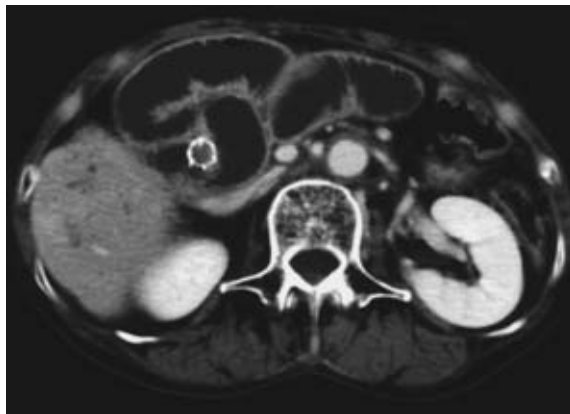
Abdominal computed tomography revealed a 5-cm-long fluid-dense tubular structure.
